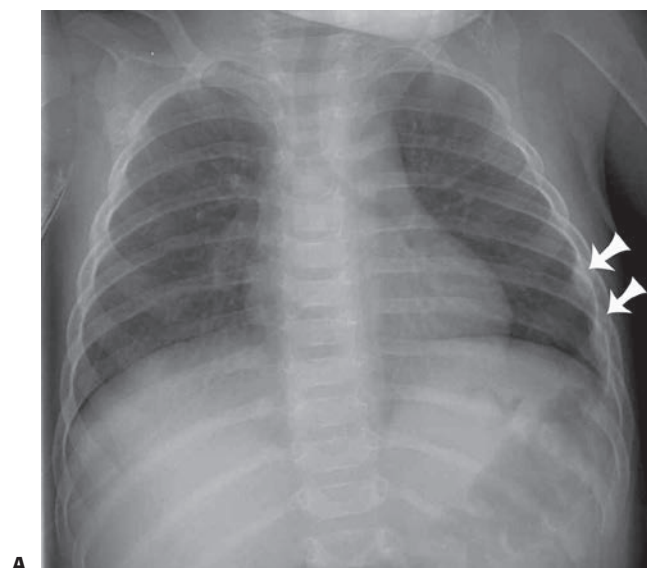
Rib fractures in a 9-month-old male victim of nonaccidental trauma. A: Chest radiograph reveals left lateral sixth and seventh rib fractures (*arrows*). B: Nuclear medicine bone scan confirms foci of increased uptake within the left lateral ribs as well as revealing additional hot foci in multiple right posterior lateral ribs.
